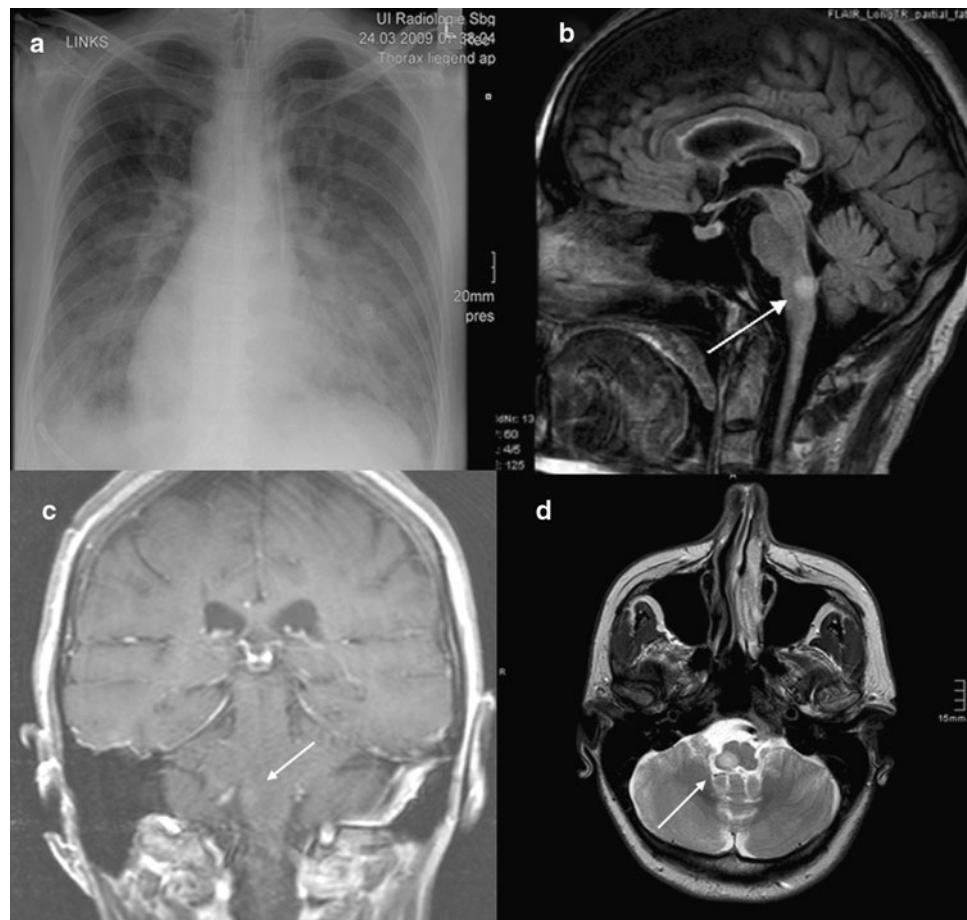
a Extensive alveolar infiltration of both lungs with symmetrical arrangement—diagnosed as a pulmonary edema. b Coronal TSE T2-weighted image (TR/TE 2900/102 ms; echo train length 7; number of acquisitions 4; matrix 192×256 ; FOV 220 mm; slice thickness 5 mm; gap 0.25) showing a hyperintense round lesion with surrounding edema parasagittal right sided within the upper medulla oblongata indicating an acute demyelinating lesion (white arrow); c after the iv administration of 0.1 mmol gadopentetate dimegлюmine per kg body weight, slight enhancement in the SE T1-weighted
